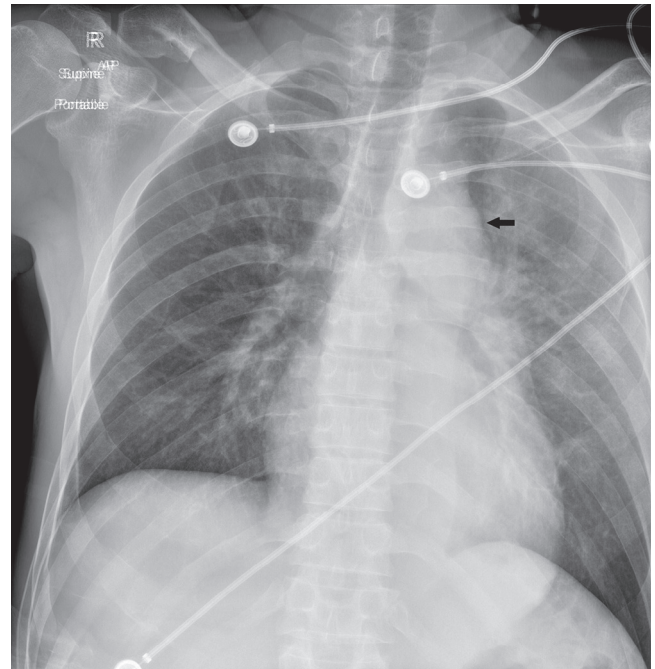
■ Traumatic aortic injury. Portable chest radiograph shows widening of the superior mediastinum, lobular contour abnormality of the transverse aorta (*arrow*), indistinct descending aorta, and opacities in the left lung consistent with pulmonary contusion/hemorrhage.
